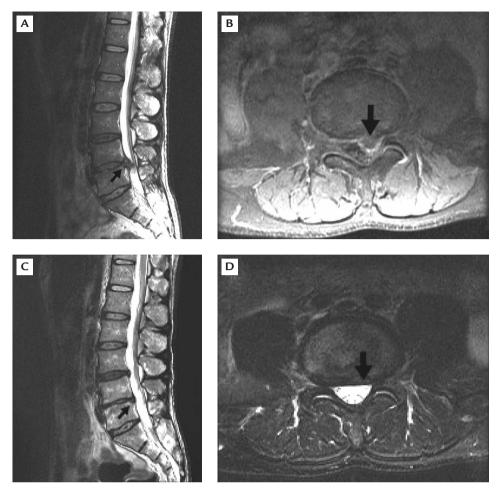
(A) Sagittal T2-weighted imaging (T2WI) of the initial magnetic resonance imaging (MRI) study revealed a large herniated disc at the L4/5 level with caudal migration. (B) Axial post-contrast T1-weighted imaging of the initial MRI showed a left-side posterolateral extruded disc fragment with marginal enhancement around the extruded disc material at the L4/5 level. (C) Sagittal T2WI of the second round of MRI showed almost complete regression of the herniated nucleus pulposus at the L4/5 level. (D) Axial T2WI of the second round of MRI showed almost complete regression of the herniated nucleus pulposus at the L4/5 level without nerve root compression.
